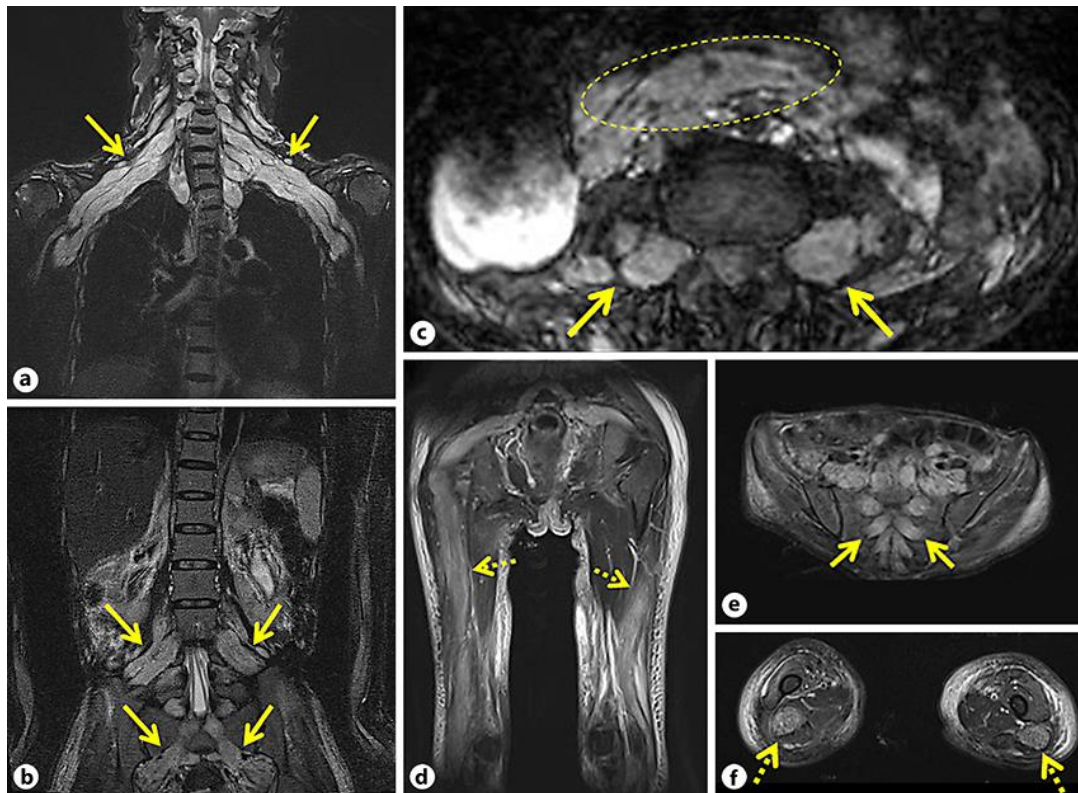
Magnetic resonance images. Cervical plexus (a), lumbar plexus (STIR TR 2850 TE 89) (b), abdomen (Tfisp MPR TR 272.89 TE 2.15) (c), lower limbs (d), pelvis (e), and thighs (STIR TR 4200 TE 68) (f). These images show hypertrophy of the cervical, lumbar, and sacral plexus (solid arrows), a retroperitoneal tumor around the abdominal aorta and celiac artery (dashed circle), and hypertrophy of the sciatic nerve (dashed arrows).
